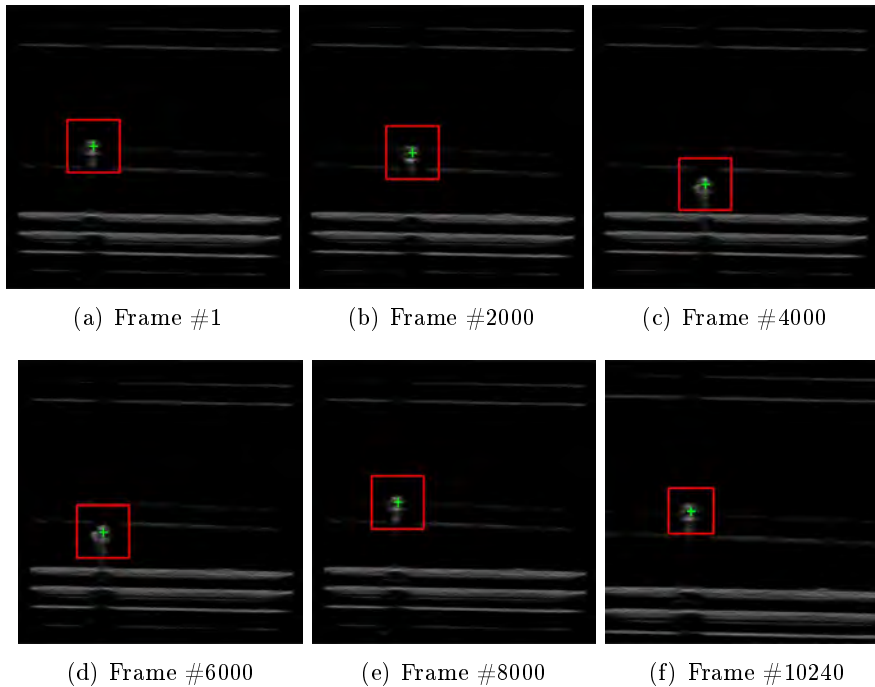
Template based tracking results of a flexible catheter in 2D transverse ultrasound images.
